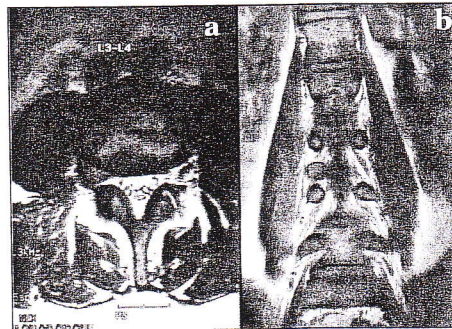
Right L4-L5 foraminal herniation on MRI.
